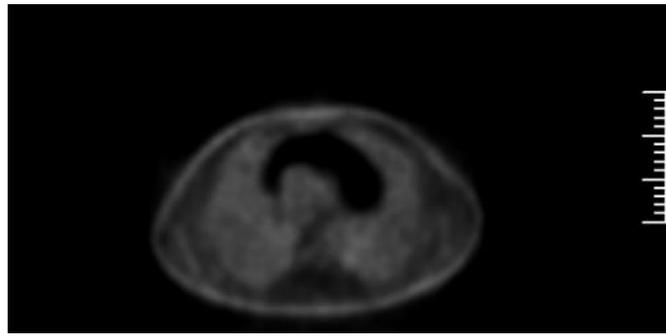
CT, PET, and PET/CT images demonstrate no homogeneous 18F-FDG uptake in anterior mediastinal mass of lobulated contour.
